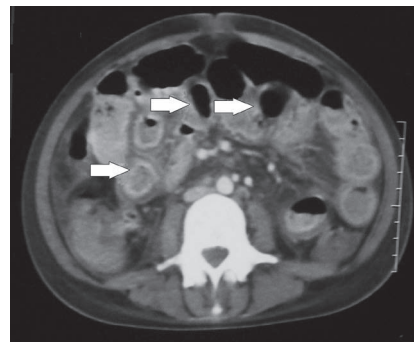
A CT scan revealing abdominal cocoon due to clumping of the intestines (arrows).
